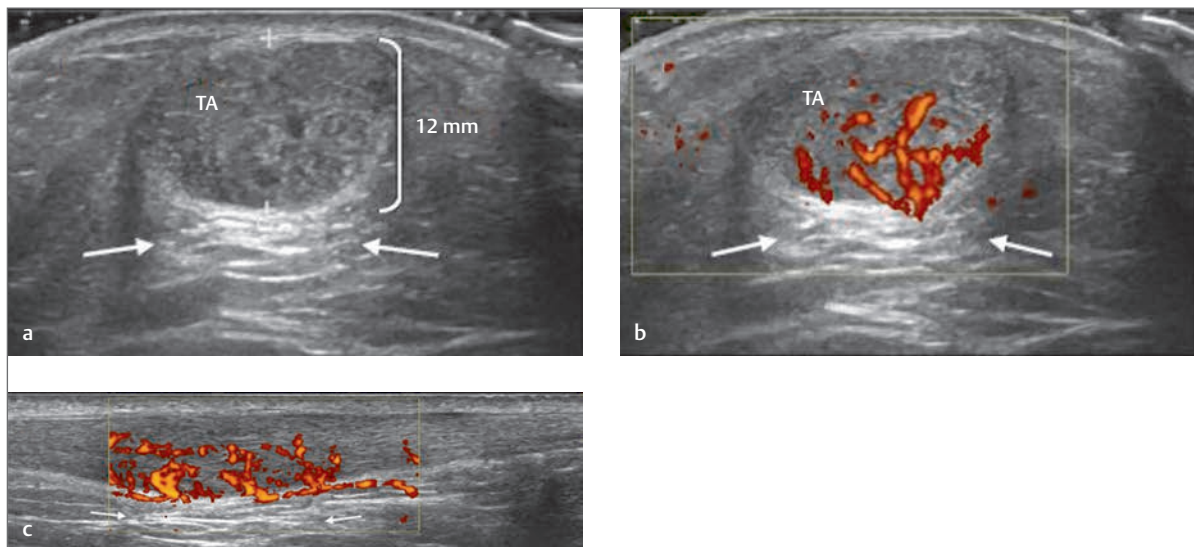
(a,b) Transverse images of the midsubstance of an Achilles tendon (TA). The tendon appears thickened at over 12 mm. In addition, there is marked posterior enhancement indicating lack of normal tendon density (*white arrows*). In part (b) Power Doppler demonstrates a marked neovascularity. (c) Longitudinal image of the same tendon as in parts (a) and (b) clearly demonstrating the spindle-shaped swelling of the tendon and a diffuse neovascularity. These findings are indicative of a midsubstance tendinopathy. White bracket, maximum tendon diameter (AP).
